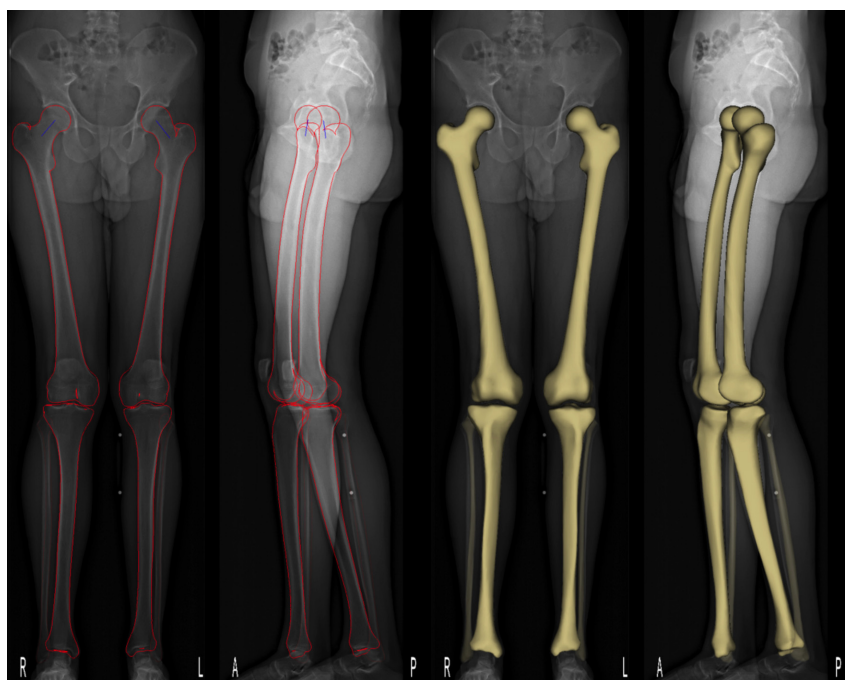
Three-dimensional reconstruction of the lower extremities based on ultra-low-dose biplanar radiographs. Bone models are manually adjusted to the osseous contours on the frontal and lateral radiograph (red lines on the left side of the figure). Upon identification of the osseous contour, the computer calculates a 3D model of the bones that is then superimposed on the original radiographs (right side of the figure). Additional measurement such as leg axis, leg length, and femoral and tibial torsion are generated automatically with this method. Figure 7 can be viewed online in color at www.investigativeradiology.com.
